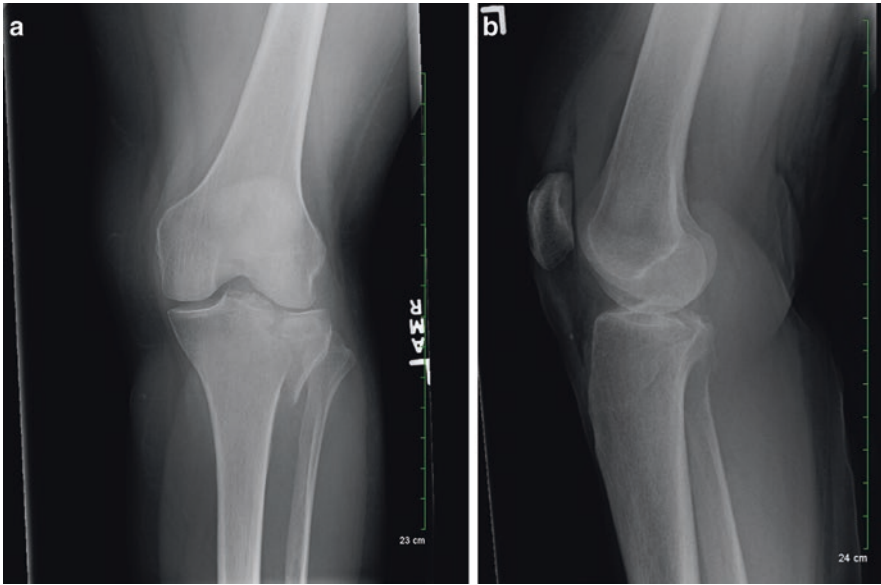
(a) AP Radiograph of the left knee (b) Lateral Radiograph of the left knee
